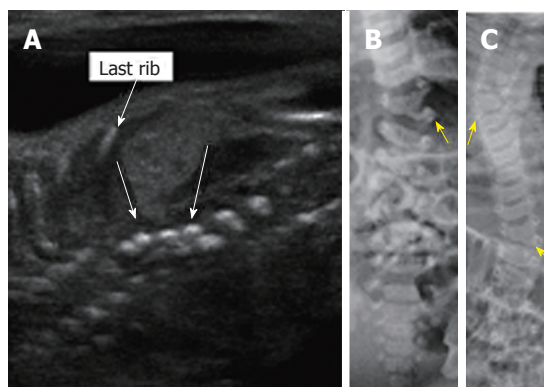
Thoracic hemivertebrae. Parasagittal grayscale ultrasound image (A) of a 20 wk fetus acquired with a high frequency linear transducer demonstrate unpaired echogenic structures at the thoracolumbar junction representing hemivertebrae (arrows). Postnatal frontal radiographs of the same patient's spine at 0 d (B) and 3 years of age (C) demonstrate left thoracolumbar and right midthoracic hemivertebrae.
